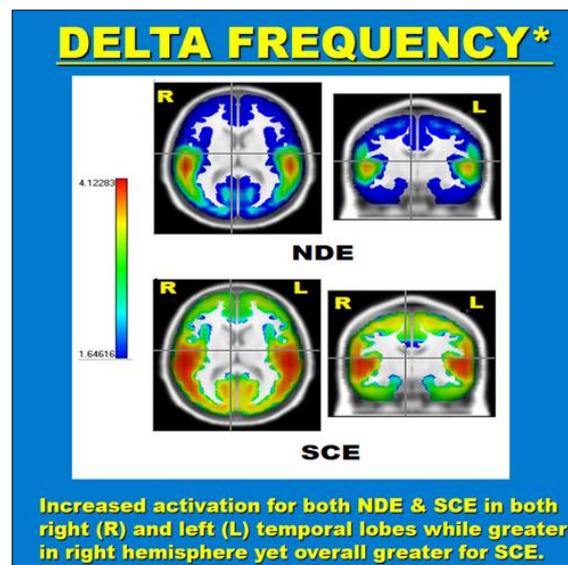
QEEGt calculated for NDE & SCE subjects over MRI slices
